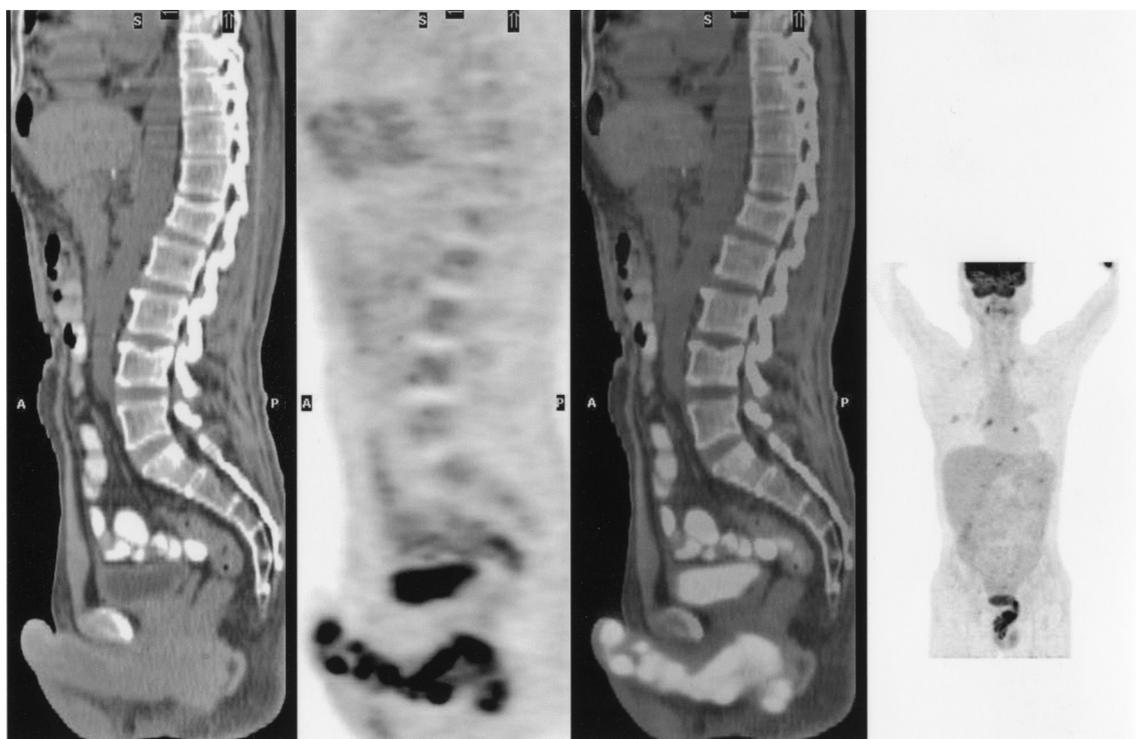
Sagittal positron emission tomography-computed tomography (PET-CT) fusion images showing a plaque of disease along the penile shaft and perineum.
